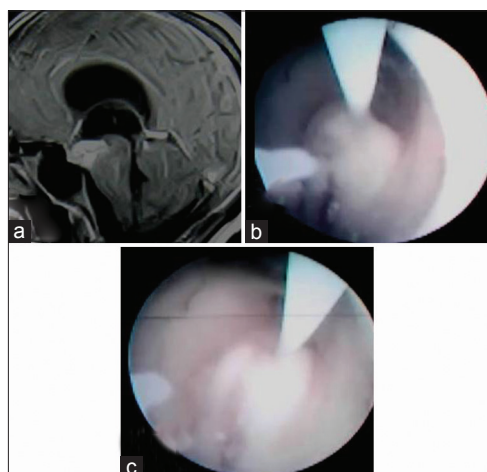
(a) Preoperative contrast magnetic resonance imaging of brain in sagittal section showing contrast enhancing lesion (tubercular abscess) in third ventricular floor and interpeduncular fossa; (b and c) per operative picture during endoscopic third ventriculoscopic interventions showing emergence of tubercular pus from the lesion
